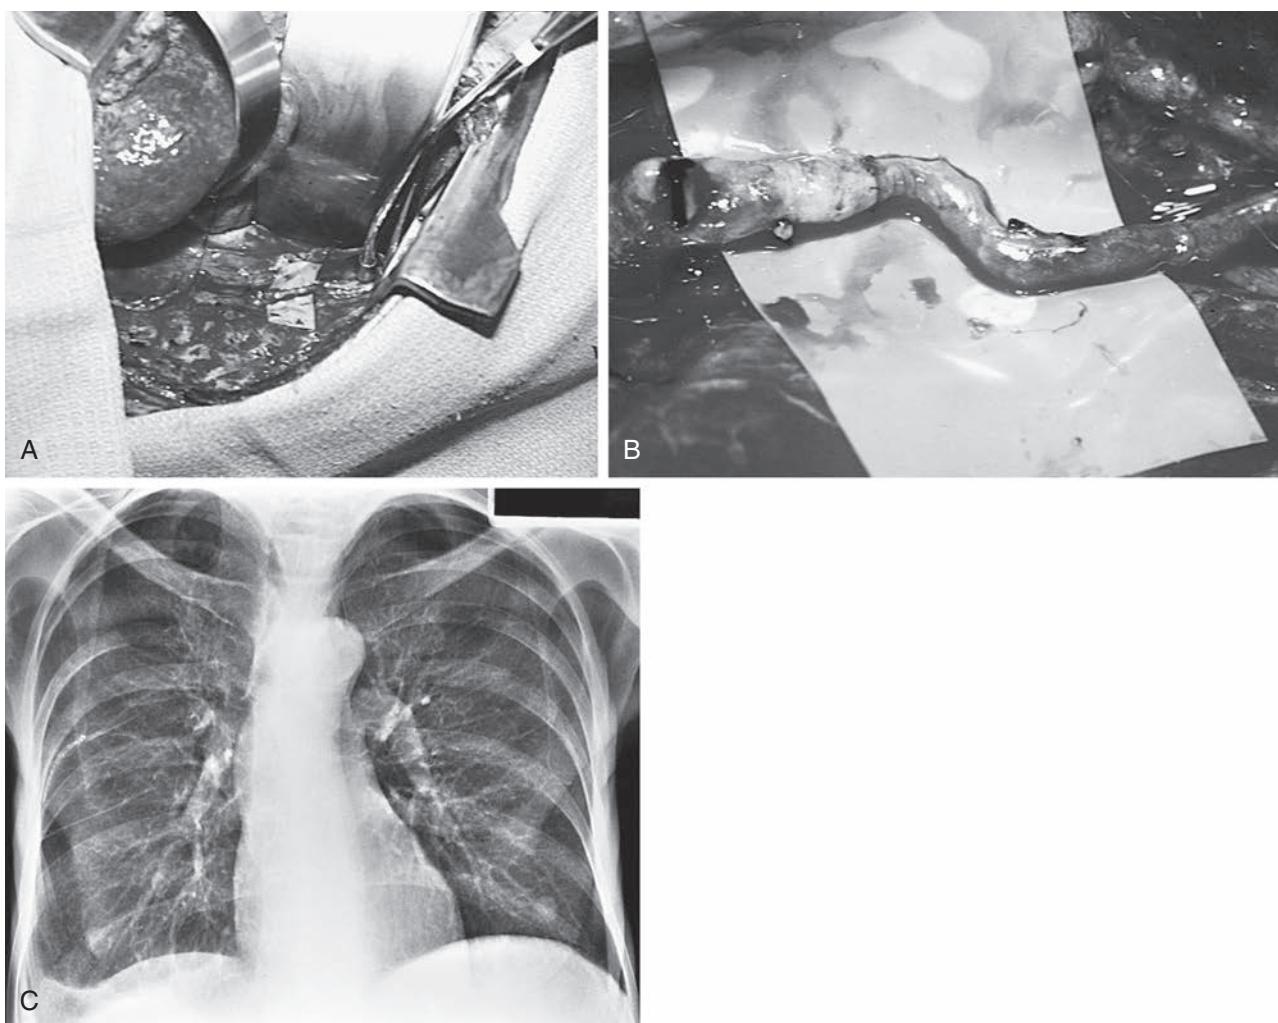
(A, B) Thoracic duct–azygos vein anastomosis performed through a right posterolateral thoracotomy in an end-to-end fashion with interrupted 8-0 polypropylene (Prolene) sutures. (C) Chest radiograph 2 years later confirms the absence of chylothorax.
